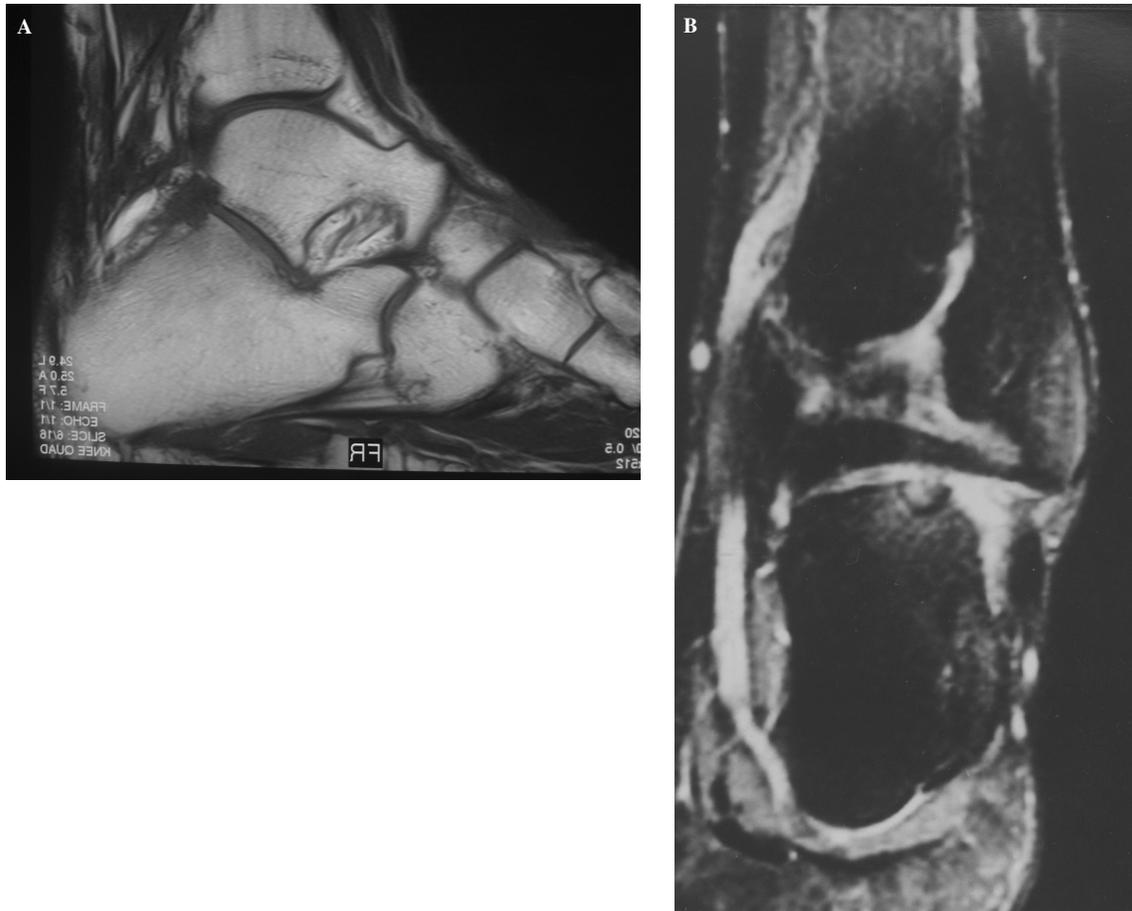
A and B, MRI showing a small lesion at the scintigraphy hotspot area.
